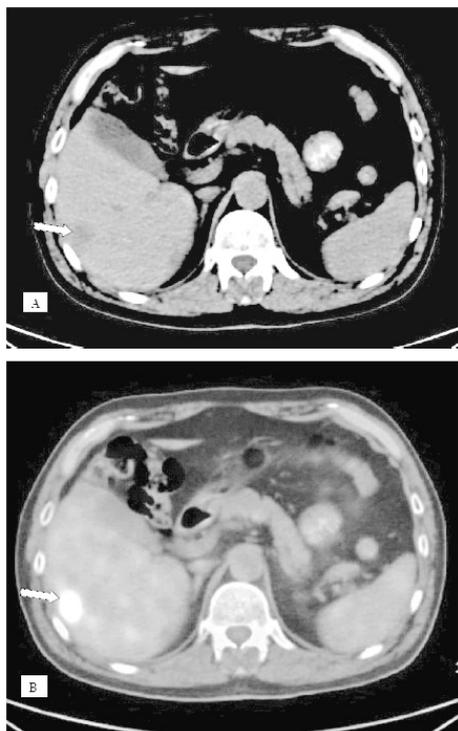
Axial plain CT (A) and 18F-FDG PET/CT fusion (B) images of a solitary hepatic metastasis of colonic adenocarcinoma. SUVmax-to-HU ratios of the metastatic lesion (arrows) and the neighbouring normal hepatic tissue were 0.280 and 0.050, respectively.
